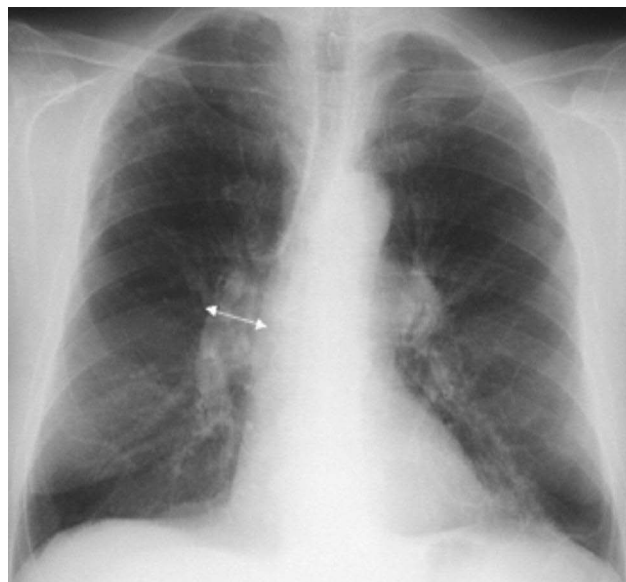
Moderate functional obstruction on respiratory function tests of a 70-year-old patient. X-ray picture of emphysema with pulmonary hyperinflation and thinning of the vascular pattern (arterial deficiency) with hypertension of the small circulation documented by the dilatation of the descending branch of the right pulmonary artery (arrow).
